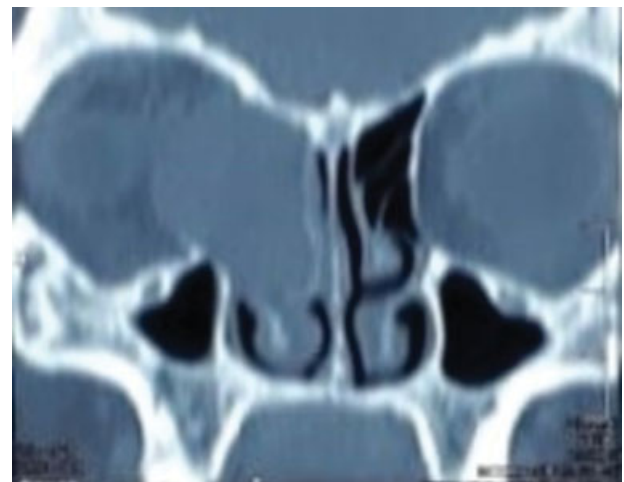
Paranasal sinuses computed tomography coronal section depicting proptosis of the right eye resulting due to right ethmoid mucocele causing erosion of the right lamina papyracea.
